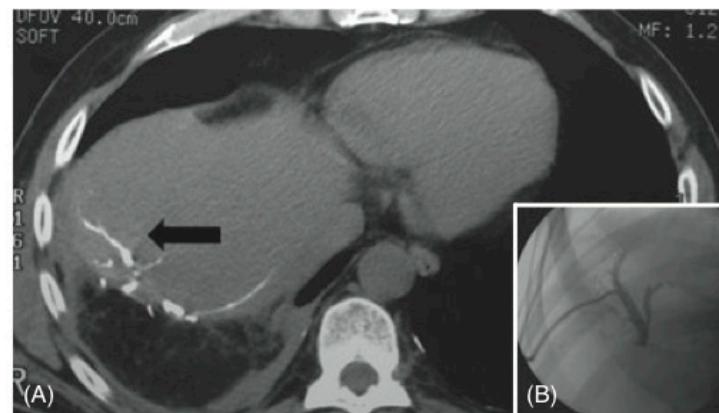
(A) Plain computed tomography performed after percutaneous cholangiography shows a communicating biliary fistula adjacent to the resected surface of the liver (black arrow). (B) Percutaneous cholangiography demonstrating no communication between a dilated intrahepatic bile duct and the principal bile duct
